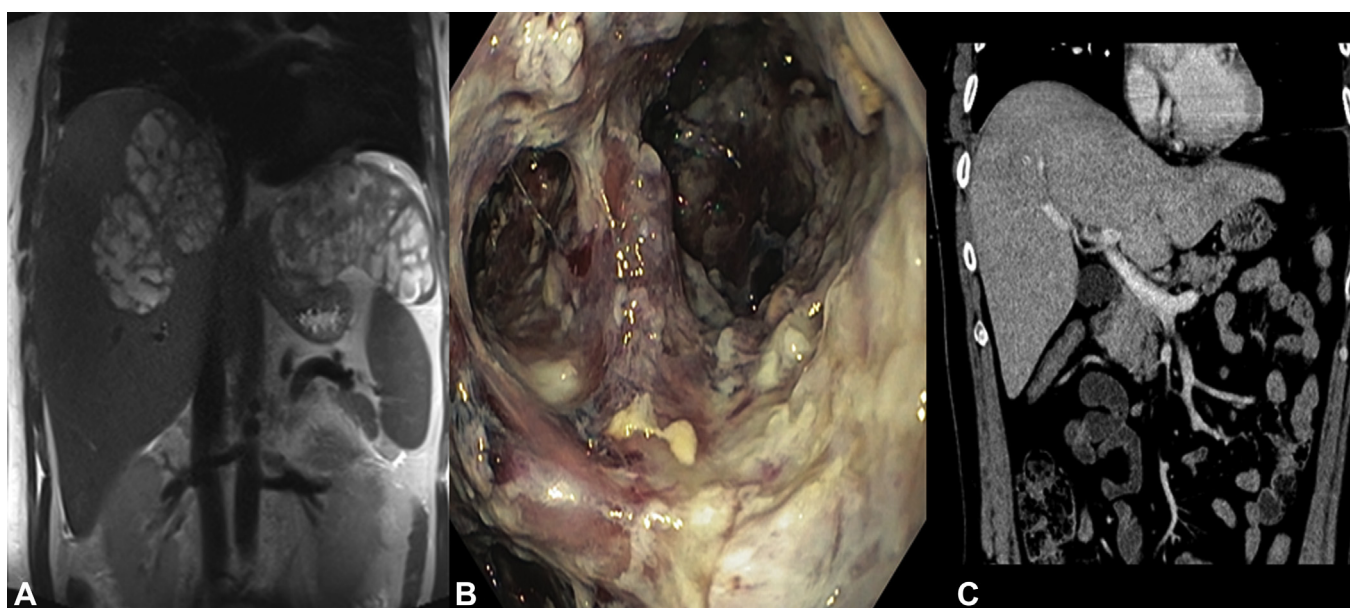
Successful endoscopic debridement and washout of bilateral hepatic abscesses over a series of 4 percutaneous necrosectomies. A, Enhanced MRI of the abdomen at the initial evaluation showing a large pyogenic abscess burden involving the right and left liver. B, The interior of the left liver abscess cavity as seen endoscopically during percutaneous debridement and lavage. C, CT imaging at 10 weeks from the first procedure confirming complete resolution of both liver abscesses.
